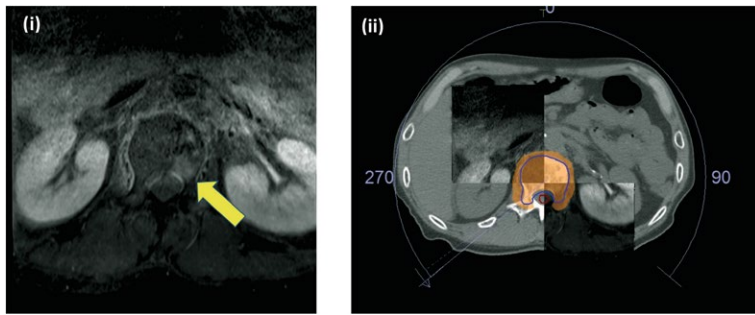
(B) [i] Metastatic deposit in L1 vertebral body (yellow arrow), as shown on T1 Axial MR (with gadolinium contrast); [ii] stereotactic body radiotherapy (SBRT) planning image (CT, MRI fused). SBRT 27 Gy in 3 fractions, delivered using volumetric modulated arc therapy. Clinical target volume (CTV) (blue outline), planning organ at risk volume (PRV)_cord (red outline), 95% isodose (orange colourwash).
